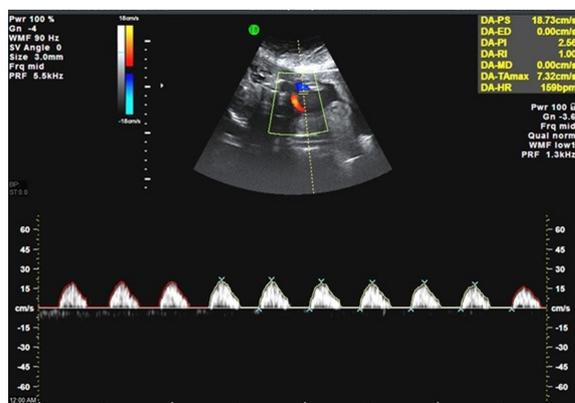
Abnormal color Doppler umbilical artery waveform demonstrating absent end-diastolic frequencies.
